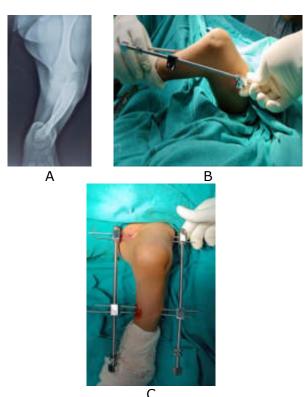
A, B & C Pre op Xray and intra op picture
